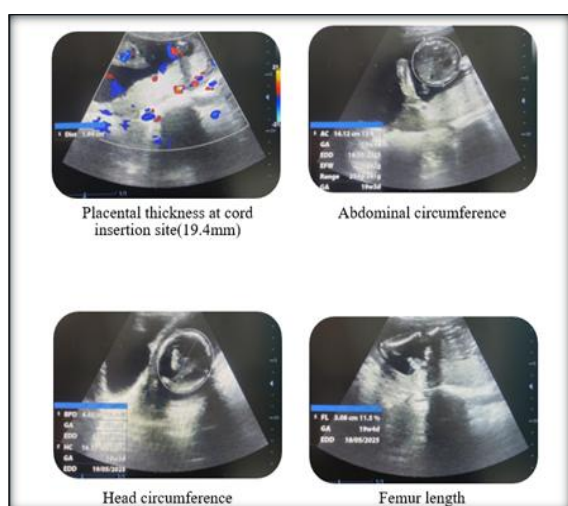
Case 2 showing Ultrasonographic Assessment of Placental Thickness and Fetal Biometry at 21 Weeks Gestation
